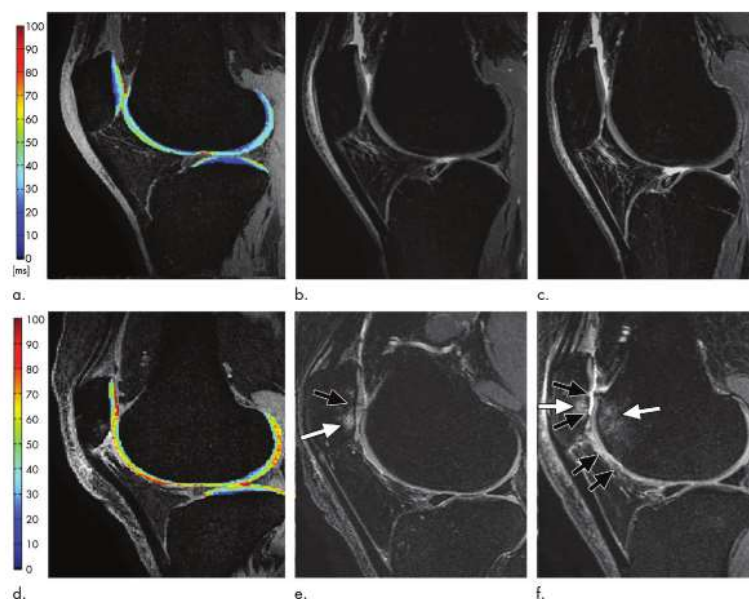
Baseline T1 ρ maps and knee MRI images showing the difference in cartilage degeneration progression between a patient without progression (top) and a patient with progression (bottom) over 2 years. In the progressive case, baseline T1 ρ values were higher, and after 2 years, severe thinning to complete loss of cartilage was observed, accompanied by an increase in subchondral bone marrow lesions (Ehmig et al, 2023).
